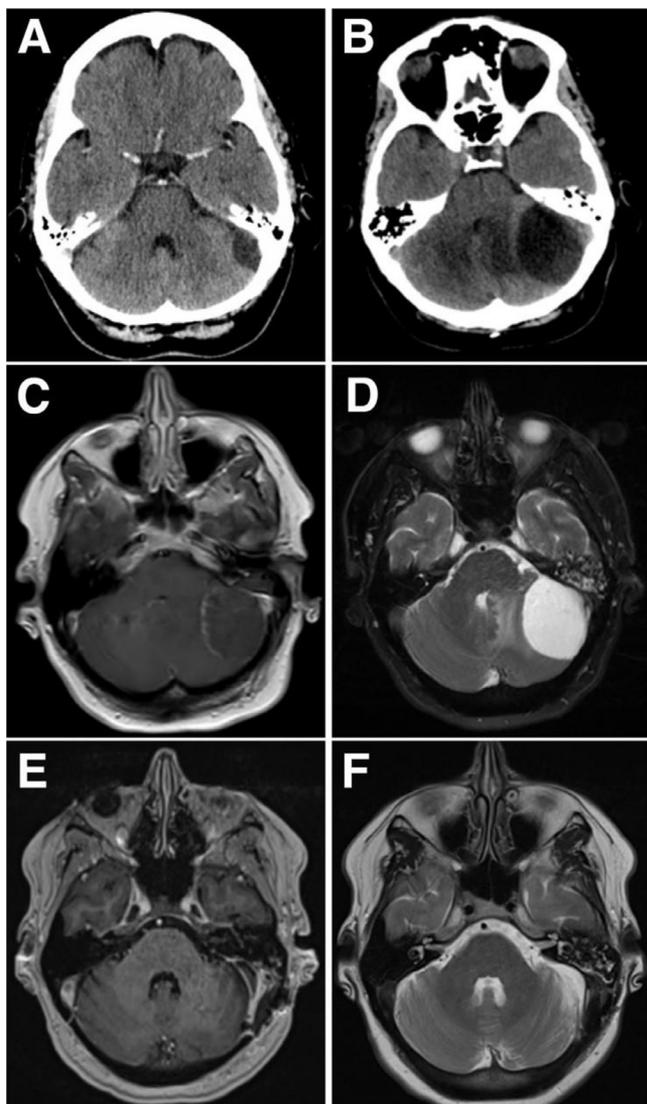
Computed tomography (CT) and brain magnetic resonance imaging (MRI) findings of a 55-year old female with a posterior fossa microcystic meningioma. Initial axial CT head demonstrates a nonenhancing cystic lesion in the left posterior fossa (A) with subsequent enlargement, fourth ventricular effacement, and perilesional edema 5 years later (B). Axial MRI demonstrates a T1-weighted hypointense (C) and T2-weighter hyperintense (D) extra-axial mass attached to the left tentorium. Axial MRI completed after resection demonstrates no mass on T1-weighted imaging (E) and complete resolution of perilesional edema on T2-weighted imaging (F).
